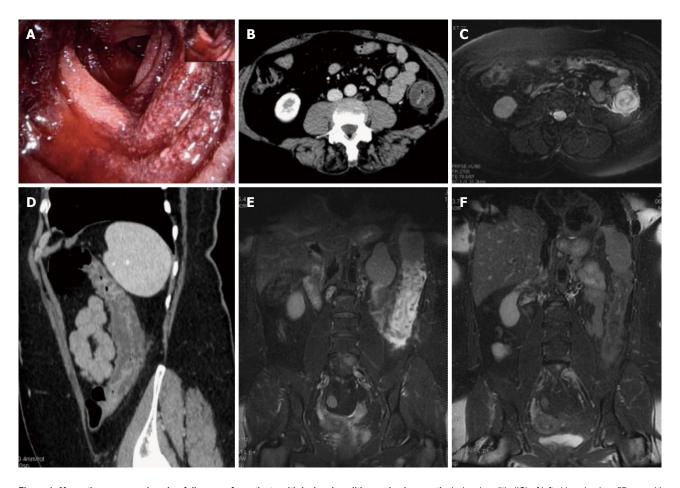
Magnetic resonance imaging follow-up of a patients with ischemic colitis resolved promptly. Ischemic colitis (IC) of left side colon in a 57 year old woman with a recent history of acute hypertensive crisis, who presented with left lower quadrant pain and massive rectal bleeding. A: Endoscopic procedure showed multiple necrotic area; B and C: Contrast-enhanced computed tomography (CT) and axial T2 fast-recovery fast-spin echo sequence (FRFSE) magnetic resonance imaging (MRI), after 32 h from CT, showed acute IC (Type I CT and MRI) with wall thickening, three layer sandwich sign and a mild amount of free fluid in the paracolic gutter; D and E: 2D coronal reformat CT and coronal T2 FRFSE MRI, at the same time, showed the entire involved tract; F: Ischemia risolved without complications with conservative therapy as shown in the follow-up MRI.
